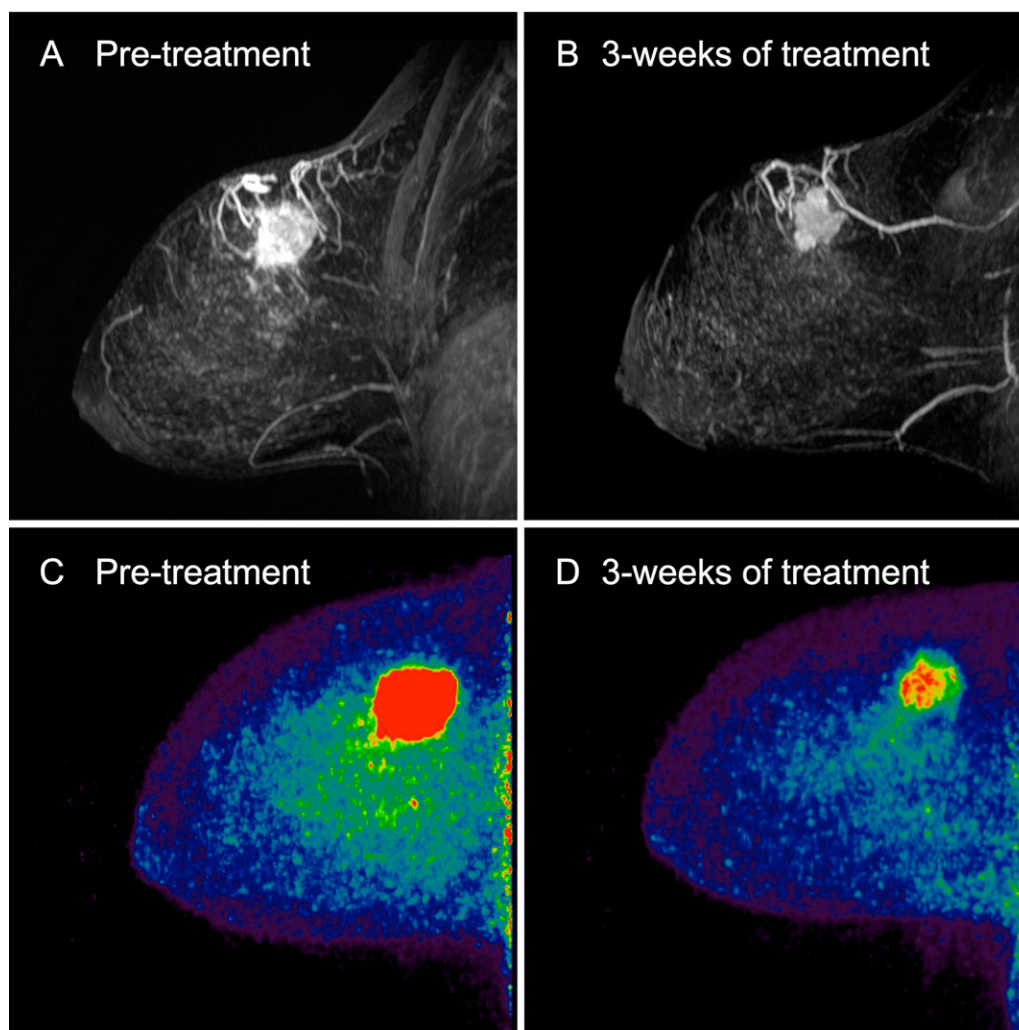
Images in a 27-year-old participant with triple-negative right breast cancer who was classified as having a treatment-responsive tumor (residual cancer burden class 0). (A, B) Sagittal maximum intensity projection postcontrast T1-weighted MRI scans show decrease in enhancing tumor volume from (A) baseline to (B) 3 weeks after treatment. (C, D) Sagittal maximum intensity projection dedicated breast PET images show decrease in fluorine 18 fluorodeoxyglucose uptake from (C) baseline to (D) 3 weeks after treatment.
